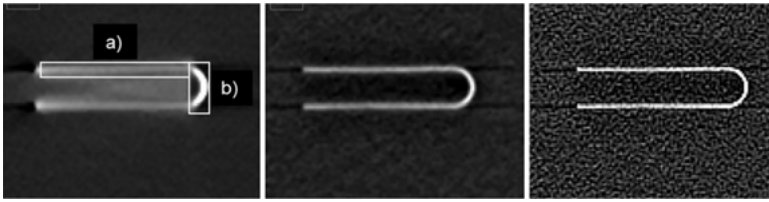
CT slice of an empty titanium IPG case lid a) and ring b). CHU with MAR (left), EHU with MAR (middle), and EHU without MAR (right).
